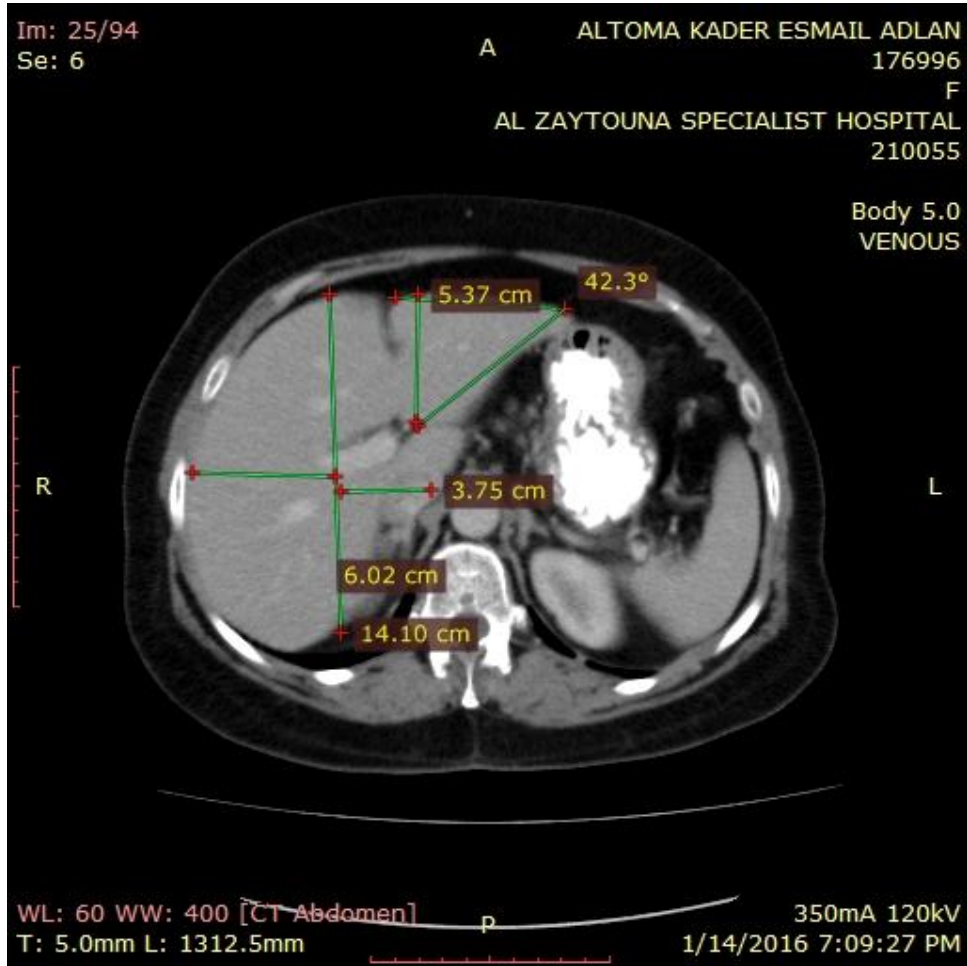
Fig CT liveraxialvenousphasethe left hepatic angle-42.3° AP diameter of the left hepatic lobe 5.37 cm diameter of the right lobe -6.02 cm diameter of the caudate lobe-3.75 cm
